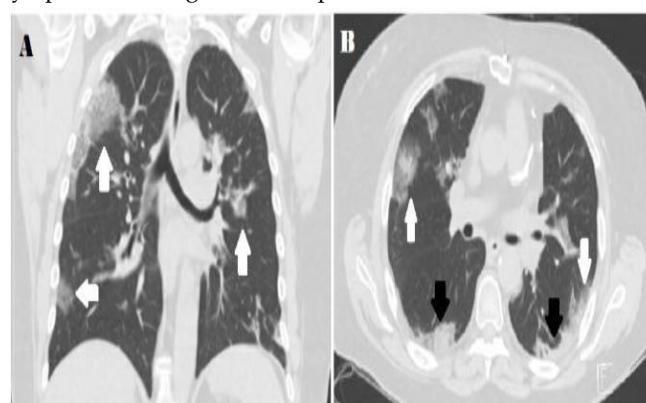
Coronal thin-section unenhanced CT image showing ground-glass opacities with a rounded morphology (arrows). B) Axial thin-section unenhanced CT scan showing diffuse bilateral confluent and patchy ground-glass (white arrows) and consolidative (black arrows) pulmonary opacities. Note the peripheral propensity.
